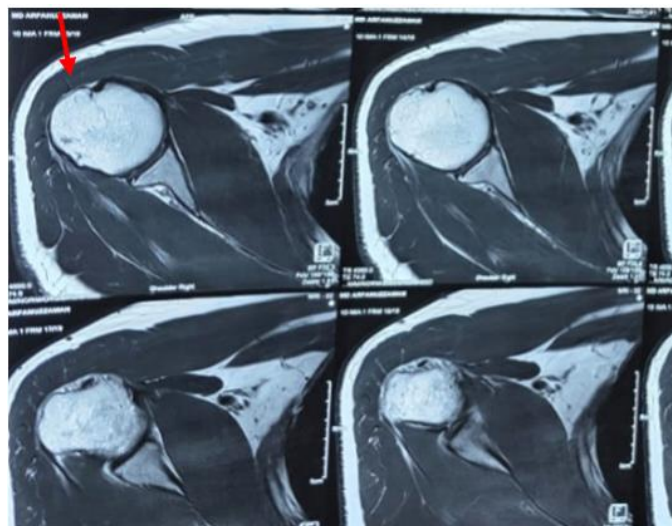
MRI axial section of right shoulder (T2 weighted image)
